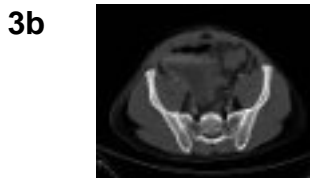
(Computed Tomography): Traumatic laceration to the pancreas. Note extensive free intra-peritoneal blood.
